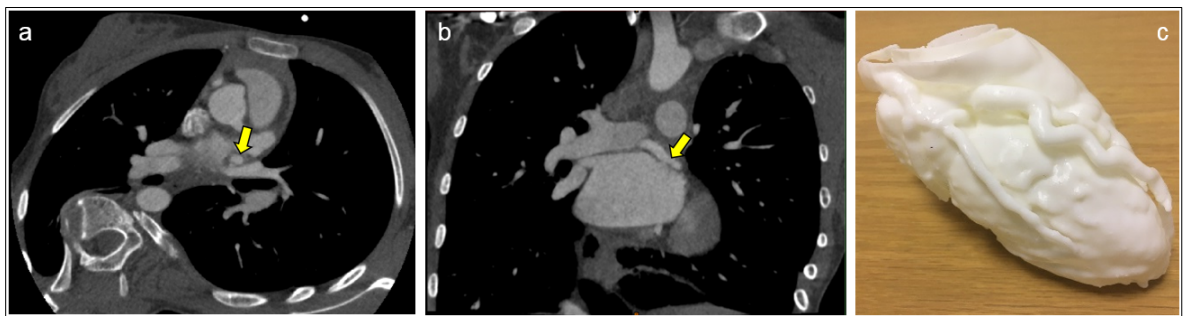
14-year-old female patient who was referred for cardiac CT after echocardiography showing prominent coronary artery flow, suggesting presence of fistula or anomalous artery connection. CT images confirmed the diagnosis of anomalous origin of the circumflex coronary artery from right pulmonary artery (a and b). 3D model was manufactured for better understanding of coronary anatomy and dimensions.
